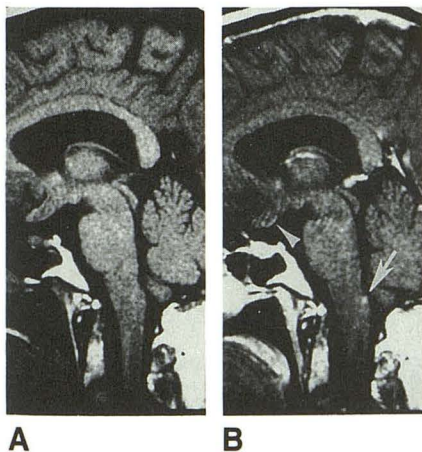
A and B, Sagittal T1-weighted MR images, SE 600/20/2, before (A) and after (B) injection of IV contrast material show small area of enhancement just dorsal to obex in area postrema (arrow). Choroid plexus of fourth ventricle is not enhanced, but pineal body is in B. Enlargement of optic chiasm and optic tracts is also present with faint contrast enhancement inferiorly (arrowhead).
